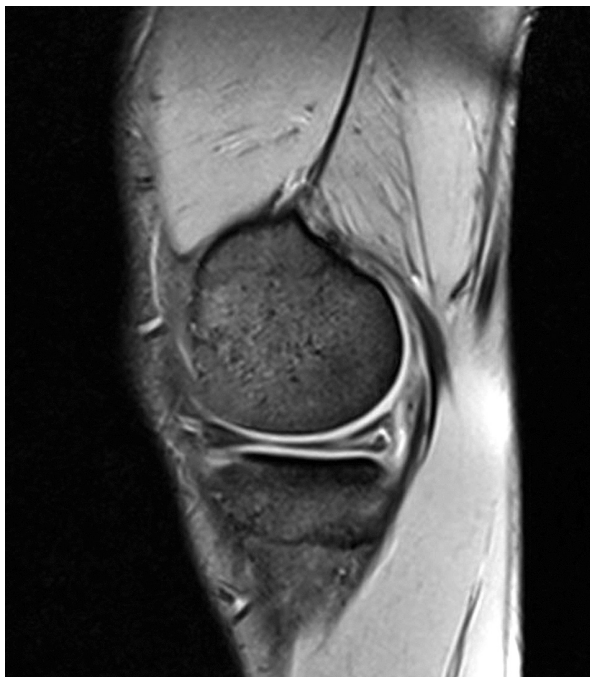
The MM posterior horn lesion in MRI
